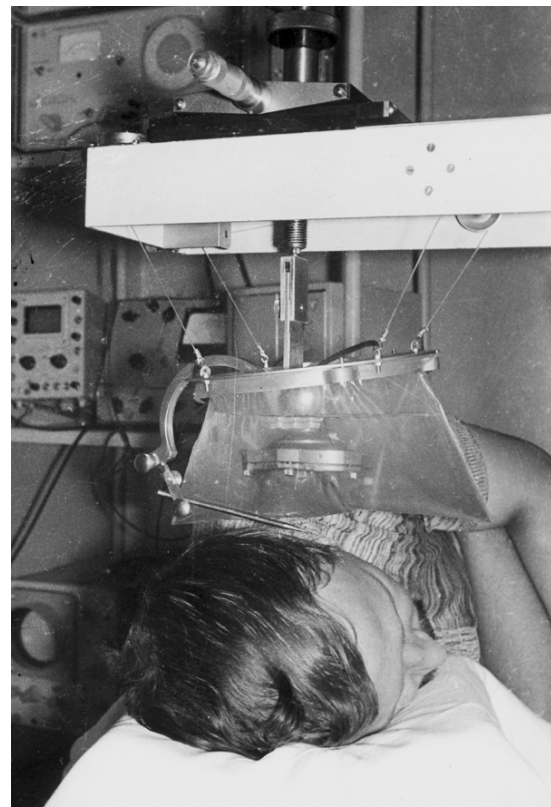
Apparatus for studying auditory sensations caused by amplitude-modulated focused ultrasound.
